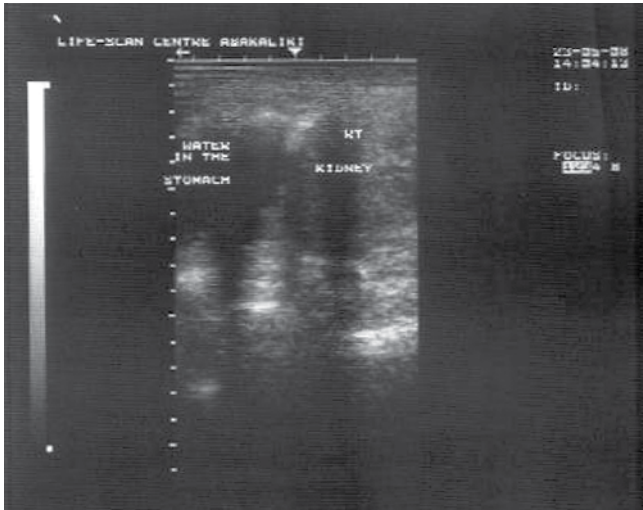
Ultrasound scan of the left upper quadrant of the abdomen showing the right kidney and water in the stomach. The spleen is absent in the splenic bed
